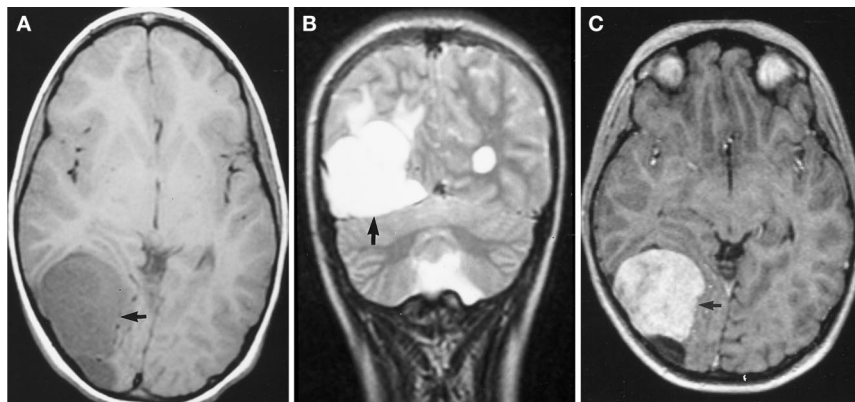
Initial magnetic resonance images showing a right posterior temporal convexity extra-axial mass in a 12-year-old girl. *A*, T1-weighted axial scan. *B*, T2-weighted coronal image. *C*, T1-weighted axial scan with contrast.
